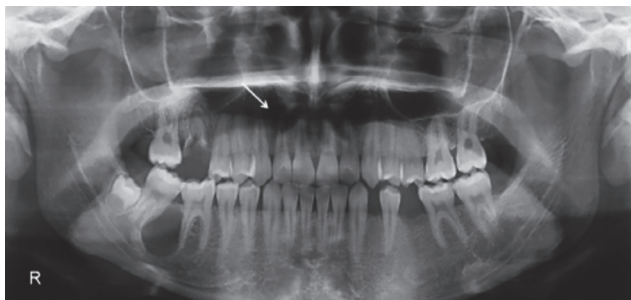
Panoramic radiograph (arrow shows periapical lesion)
